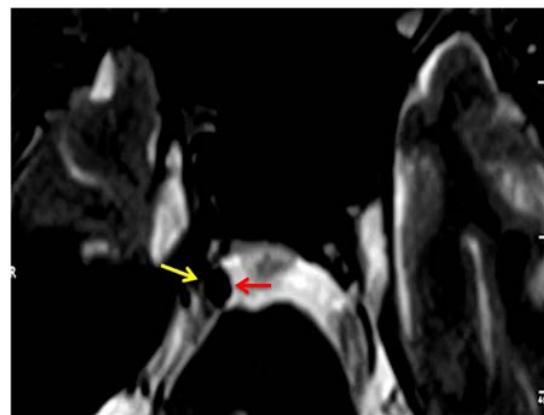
MRI aspect showing a crossing enters V and the basilar artery (red arrow) with cisternal way deviation of the nerve (yellow arrow).
